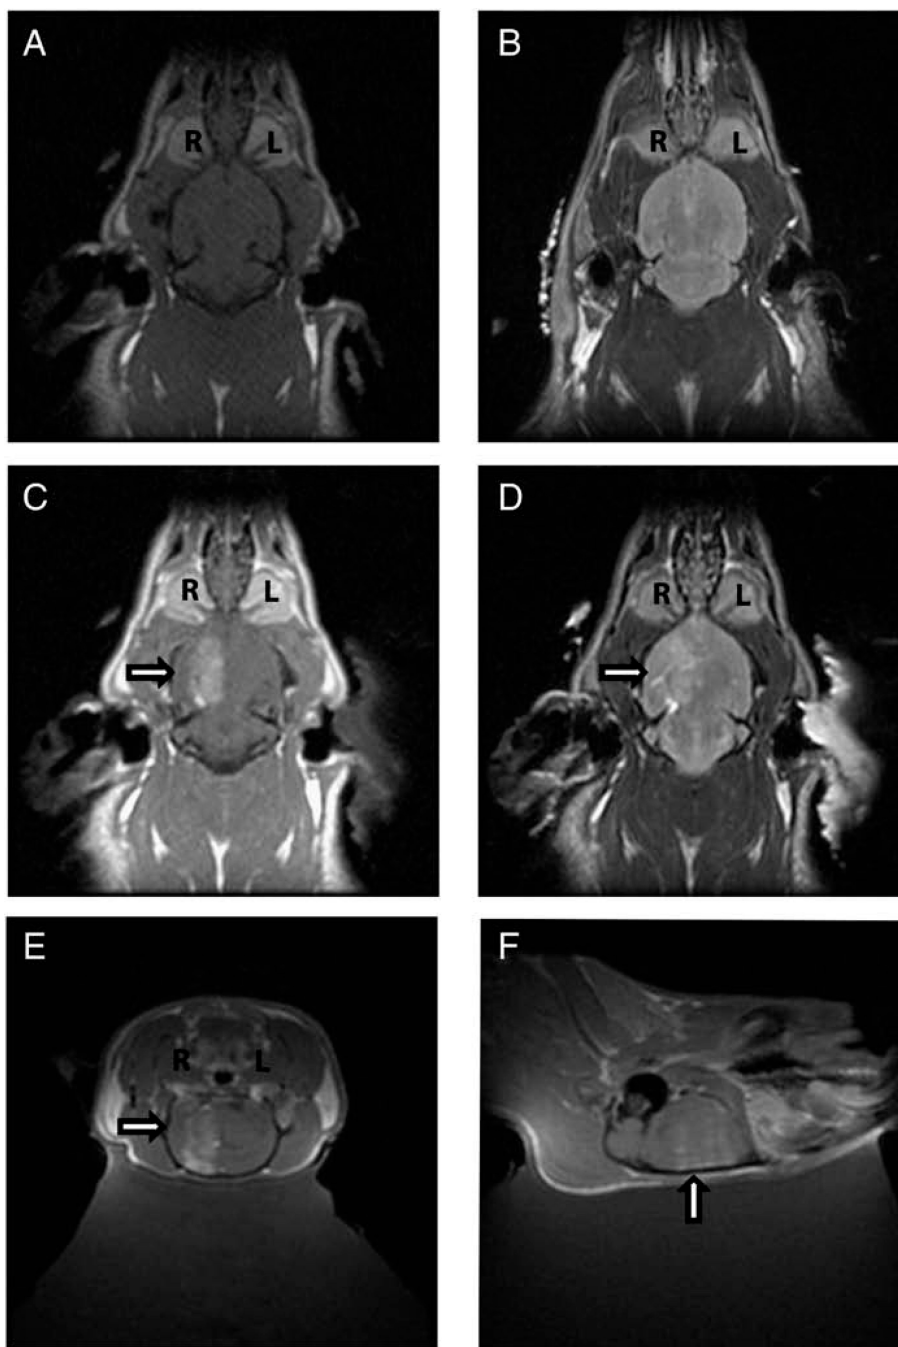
Magnetic resonance imaging (MRI) demonstrating disruption of BBB by MRgFUS (A) Contrast enhanced axial T1-weighted images prior to MRgFUS does not show extravasation of gadolinium. (B) T2-weighted axial image prior to MRgFUS shows no increased signal. (C) Contrast enhanced axial T1-weighted images following MRgFUS shows extravasation (arrow) of gadolinium in the right hemisphere (R) but not the left hemisphere (L) suggesting BBB disruption. (D) T2-weighted axial images following MRgFUS shows increased T2 signal (arrow) corresponding to area of BBB disruption in the right hemisphere (R). Contrast enhanced coronal (E) and sagittal (F) T1-weighted images
